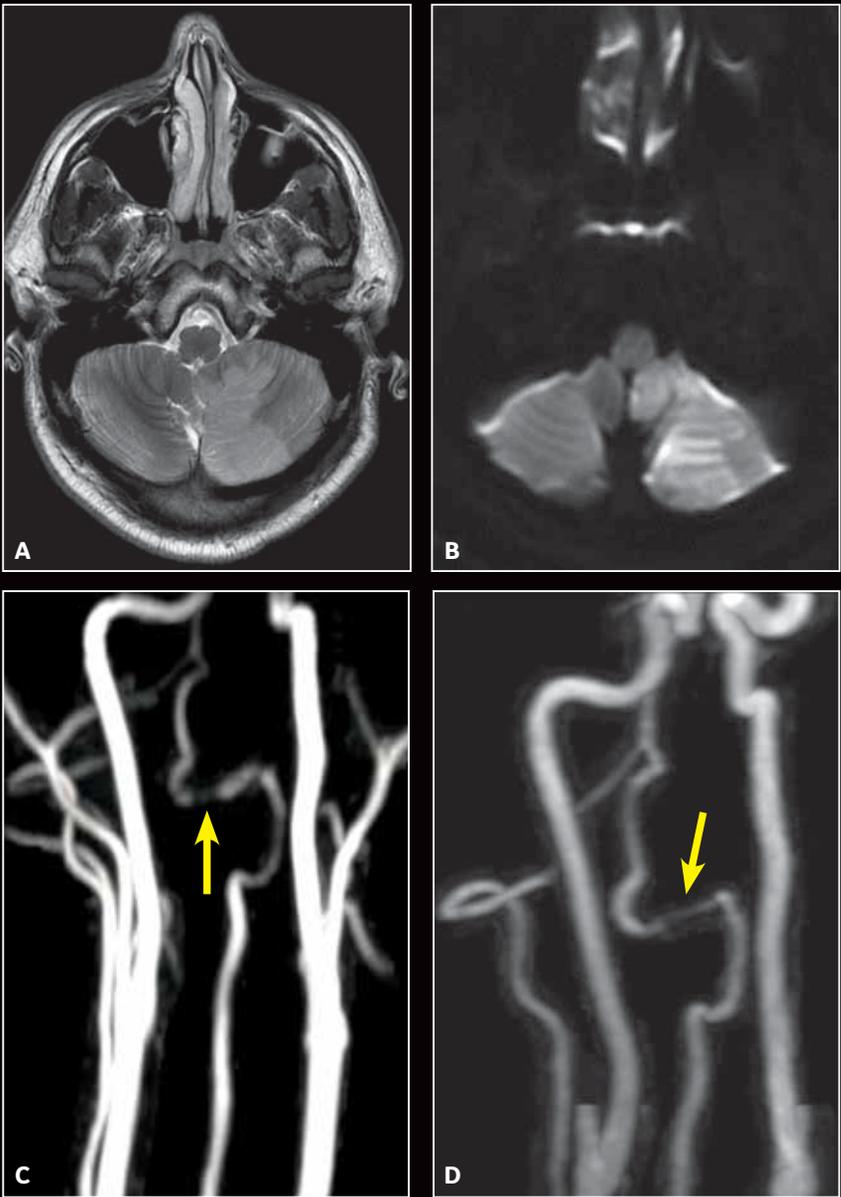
A 35-year-old patient, H/O trauma; head first/supine using the HNU coil. (A) T2w and (B) DWI showing hyperintense areas involving left cerebellar hemisphere postero-infero-medially and inferior vermis with recent onset infarct (left PICA territory). Axial DWI b1000, 160 x 160 in 48 sec. (C) 3D TOF showing a narrowing of the V3 segment of the left vertebral artery (arrow); signal loss in the region is suggestive of slow flow or turbulence. (D) 3D contrast-enhanced MRA TRICKS showing a narrowing of the V3 segment of the left vertebral artery (arrow).
